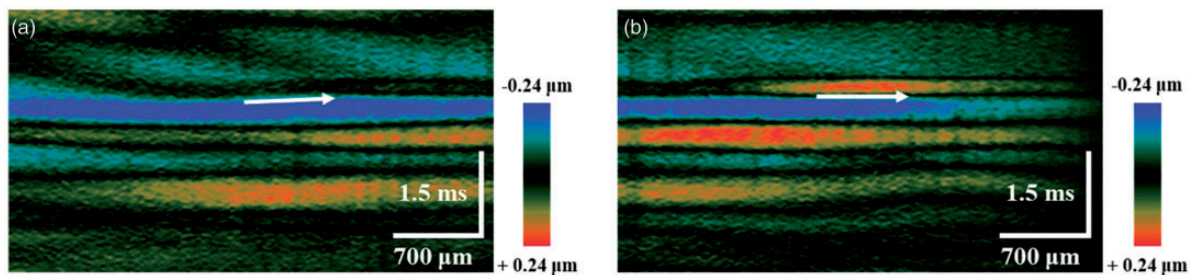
Spatiotemporal Doppler OCT images of *ex vivo* human scarred cornea. (a) Image of the scarred region and (b) image of the normal region. The direction of wave propagation is depicted by a white arrow. (A color version of this figure is available in the online journal.)
